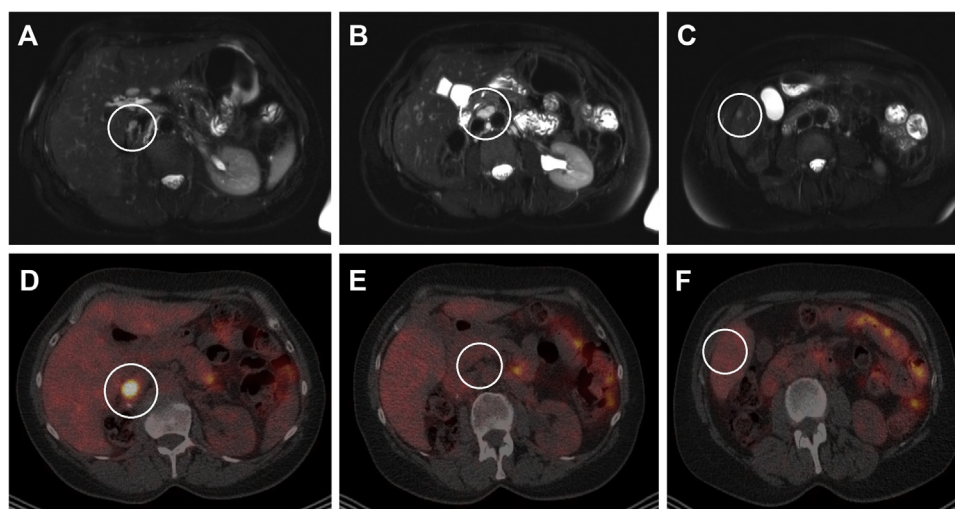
Patient #18 presented with a suspicious lesion in the inferior caval vein (ICV; 10 mm) 6 mo after nephrectomy (pT3a ccRCC with a positive surgical margin at the renal vein). CT and mpMRI (A) could not distinguish with certainty between tumor thrombus and a blood clot, and furthermore mpMRI revealed (B) several enlarged lymph nodes (short axis up to 12 mm) and (C) a liver lesion (7 mm). (D) ^{89}Zr -girentuximab PET/CT imaging showed uptake of ^{89}Zr -girentuximab in the inferior caval vein, thereby noninvasively confirming the presence of recurrent ccRCC. No uptake of ^{89}Zr -girentuximab in (E) the lymph nodes or (F) the liver lesion was seen, making ccRCC metastases less likely. Surgery was performed with resection of the lesion in the ICV (ccRCC) and several enlarged lymph nodes (benign). No change of the liver lesion was seen over 15 mo. The value of the ^{89}Zr -girentuximab PET/CT was to confirm the local recurrence and, prior to metastasectomy, provide more certainty about the enlarged lymph nodes and the liver lesion. ccRCC = clear cell renal cell carcinoma; CT = computed tomography; mpMRI = multiparametric magnetic resonance imaging; PET = positron emission tomography.
